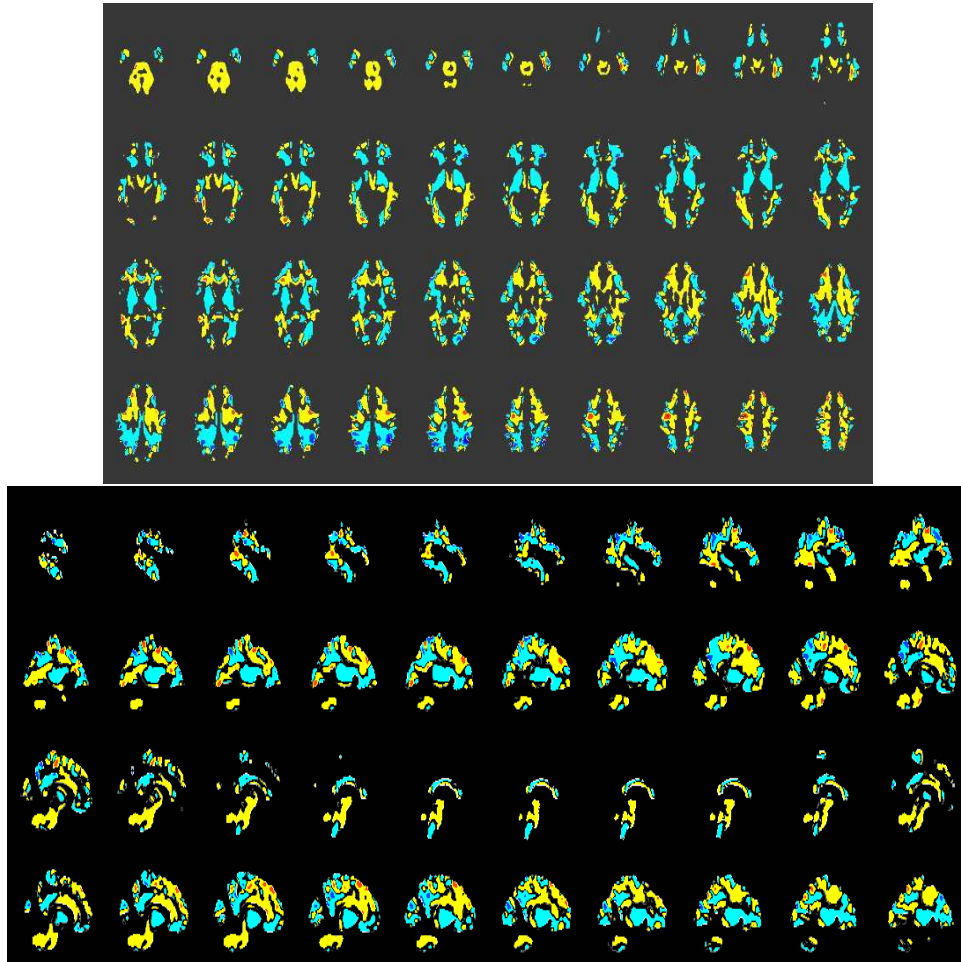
Weighted MRI of white matter volume influence. The blue and red represent opposite change influence where blue is the negative values and red is the positive values.
